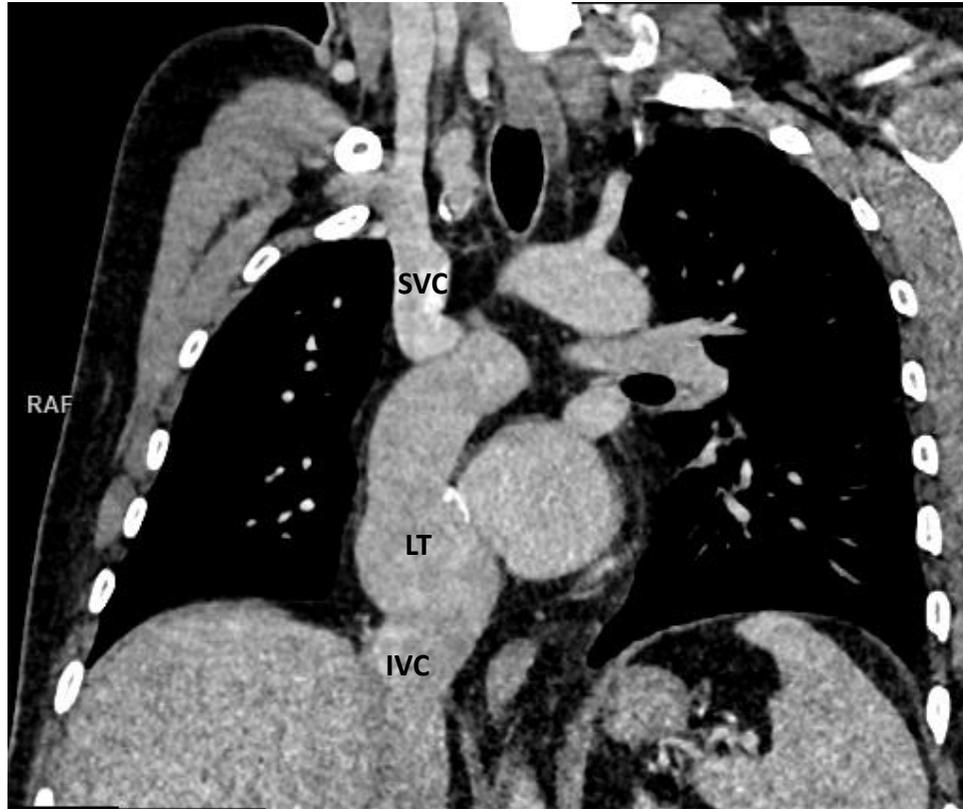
Computed tomography, coronal reformatted image – TCPC lateral tunnel
